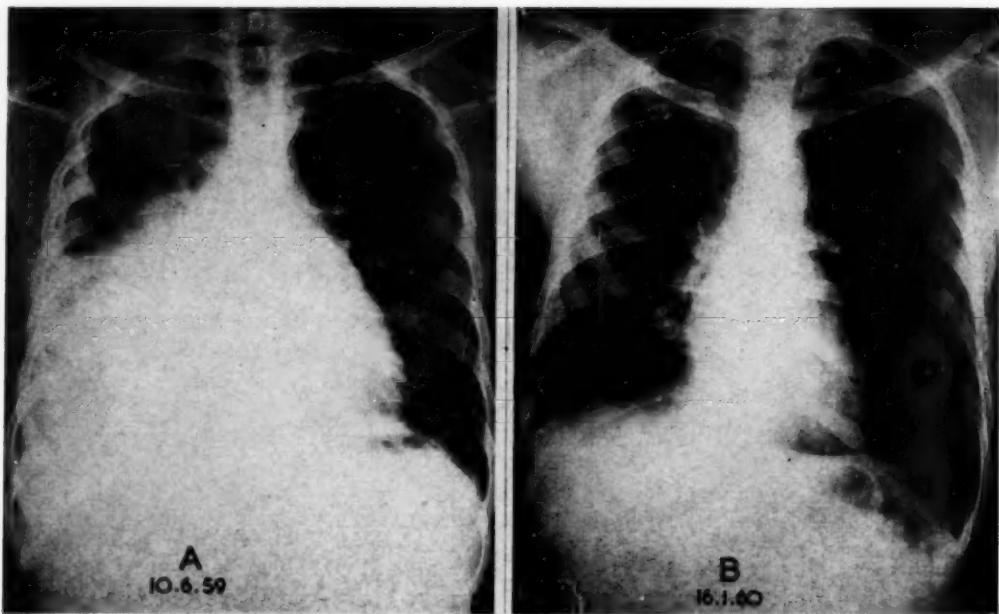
A, Preoperative chest radiograph, showing right pleural effusion and cardiac enlargement. B, Postoperative radiograph, showing restoration of normal cardiac silhouette.
